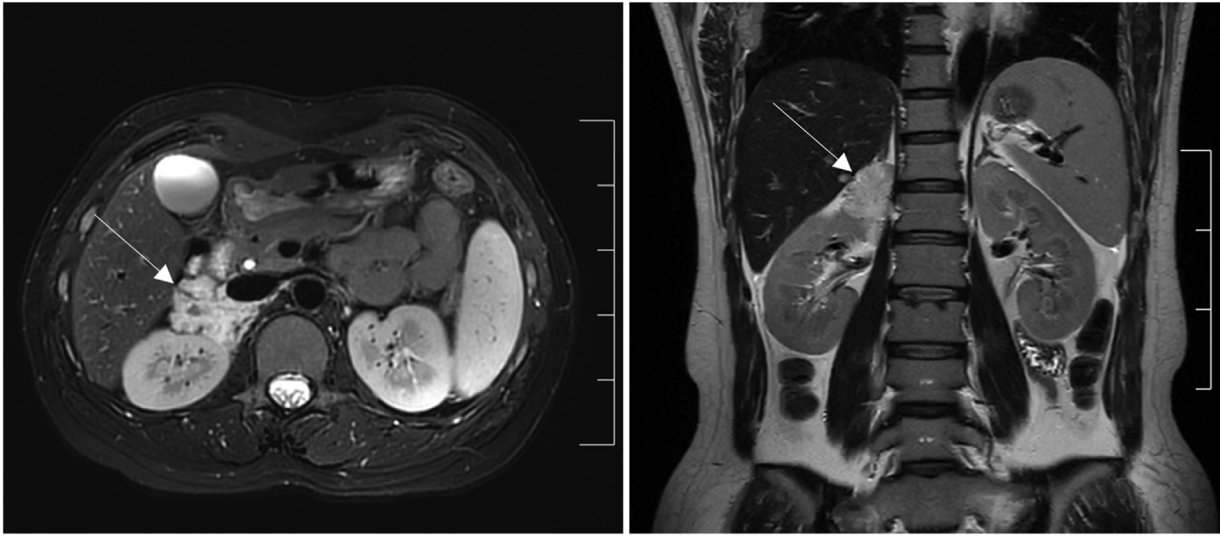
Magnetic resonance images of the retroperitoneal mass (arrow).
